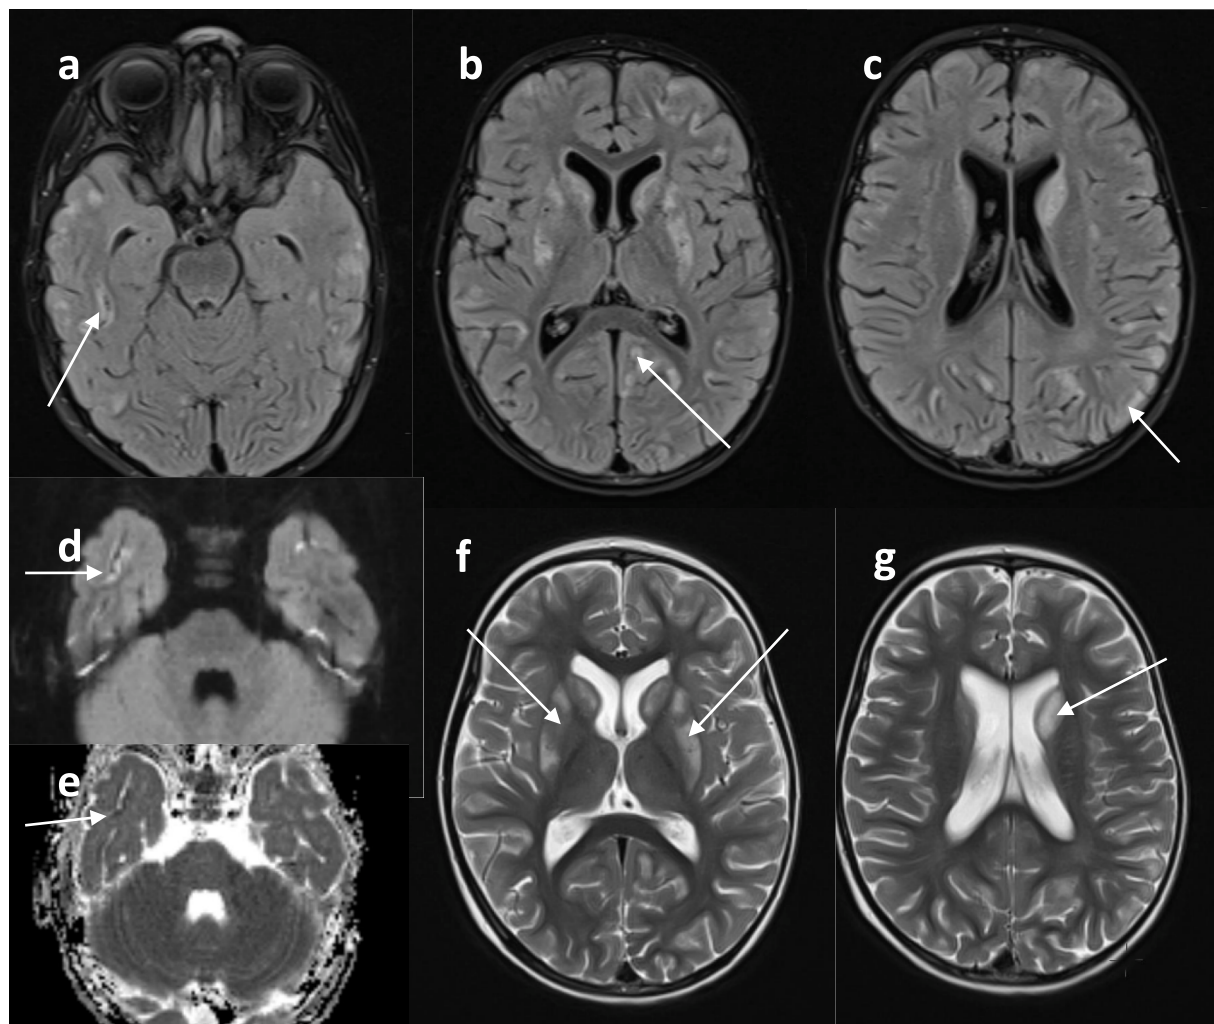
Patient 2 at the age of 2.5 years. MR brain imaging. Axial FLAIR (a, b, c), diffusion weighted image (DWI) (d), apparent diffusion coefficient (ADC) (e), and T2-weighted (f, g) images. Multiple, punctate and linear lesions are visible in both cerebral hemispheres cortex (arrows on pictures a, b, c). Some of them are hyperintense on DWI (arrow on d)) and hypointense on ADC map indicated restricted diffusion (arrow on picture e). Hyperintense signal in both putamina (arrows on picture f) and heads of the caudate nuclei is seen on pictures b, c, f, g. Additional asymmetric involvement of the caudate nuclei (arrow on picture g).
